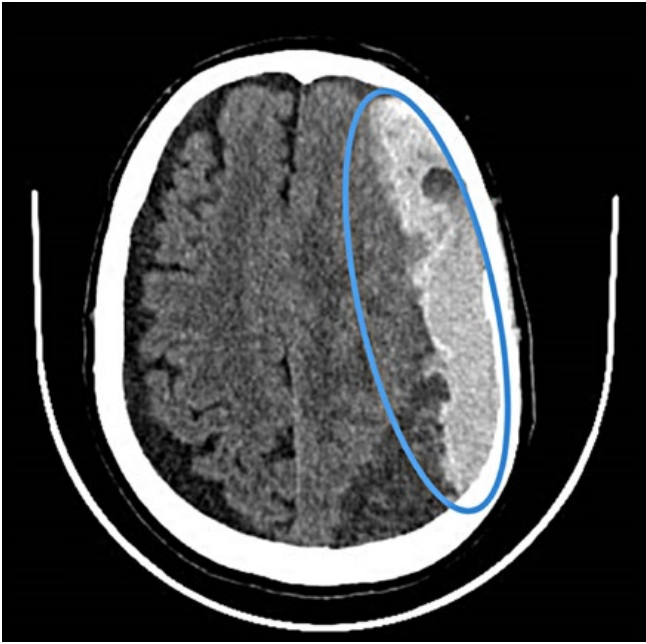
Cerebral CT scan showing an acute left subdural hematoma, causing mass effect on the adjacent sulci with a 7 mm midline shift (blue oval).
